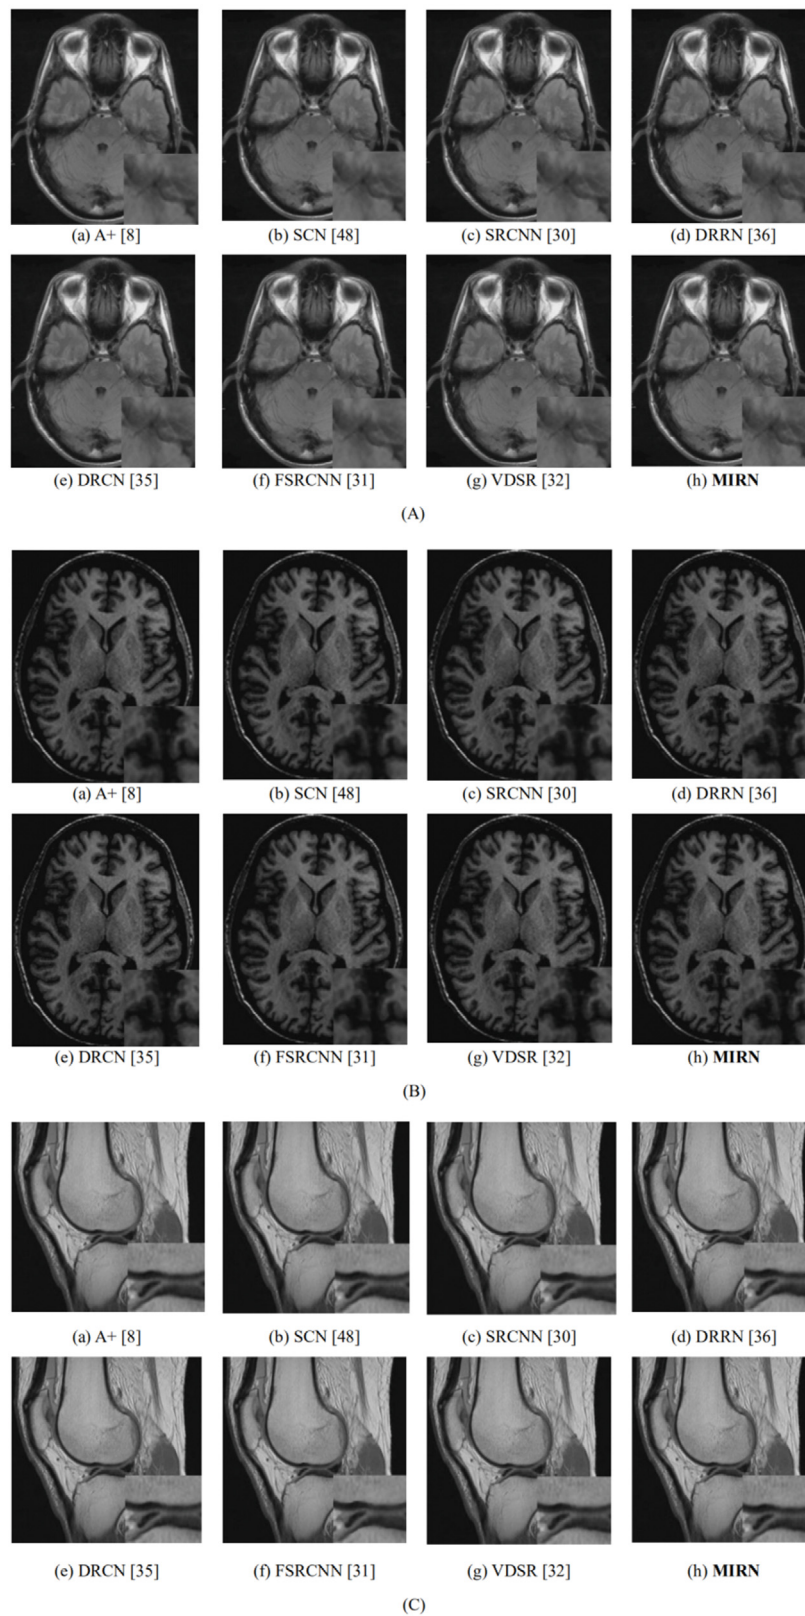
Qualitative comparison of the proposed model with other state-of-the-art methods at 4× super-resolution based on MRI images.
